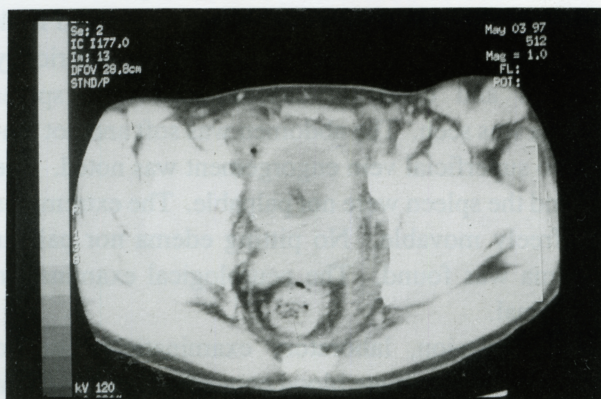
Pelvic CT scan revealing enlarged left peripheral zone of the prostate with fluid density collection.
